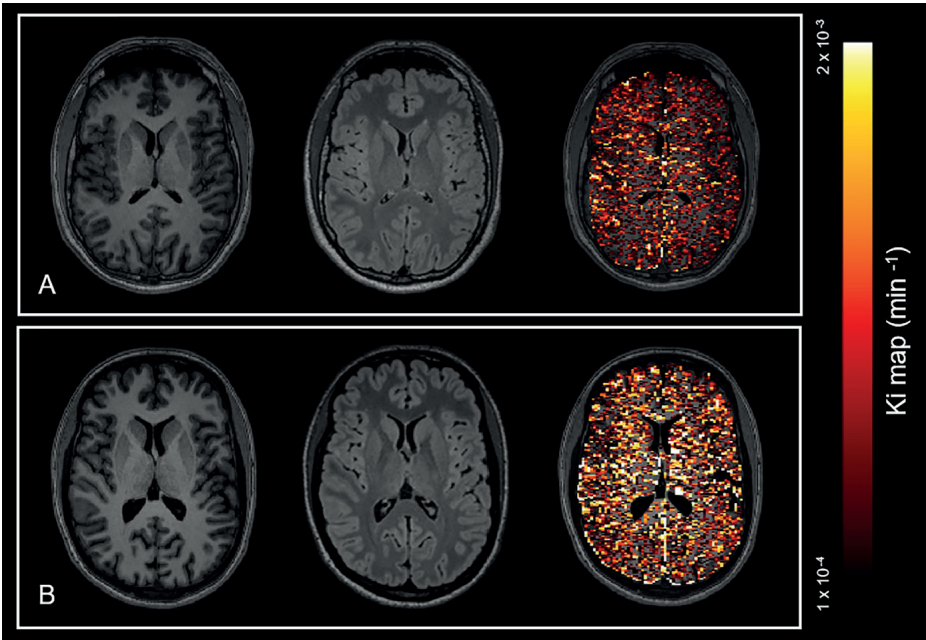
Color-coded gadolinium leakage in healthy control (A) and age-matched participant with hypertension (B). T1, FLAIR and leakage map overlaid on T1 images of 26-year-old control with blood pressure 125/79 mmHg (A) and 26-year-old participant with hypertension with blood pressure 145/94 mmHg (B). Lighter colours reflect a higher leakage rate value.
